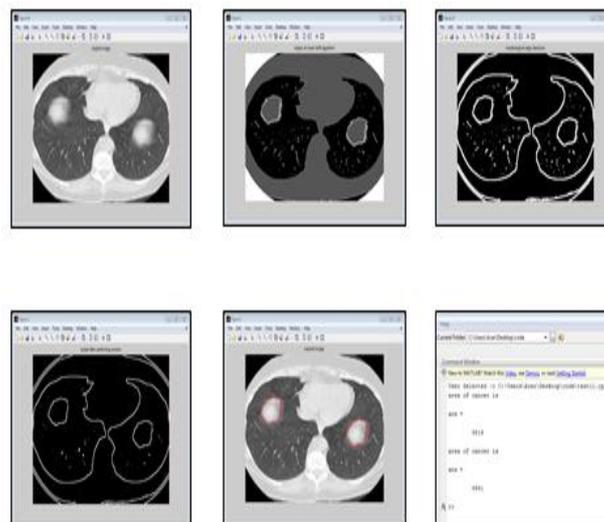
(a) Original CT image (b) Output after Mean Shift (c) Output after Dilation (d) Output after Erosion (e) Masked image (f) Area of Cancerous nodule
